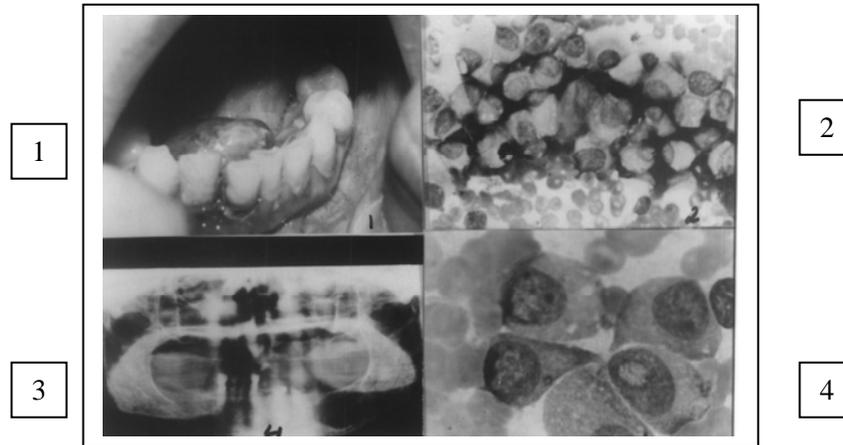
A patient with MM, (1)Sublingual mass (2) and (3) FNA smears showing sheets of myeloma cells (x 400 and x1000 respectively). (4) X-ray showing osteolytic lesion in the body of the mandible.
